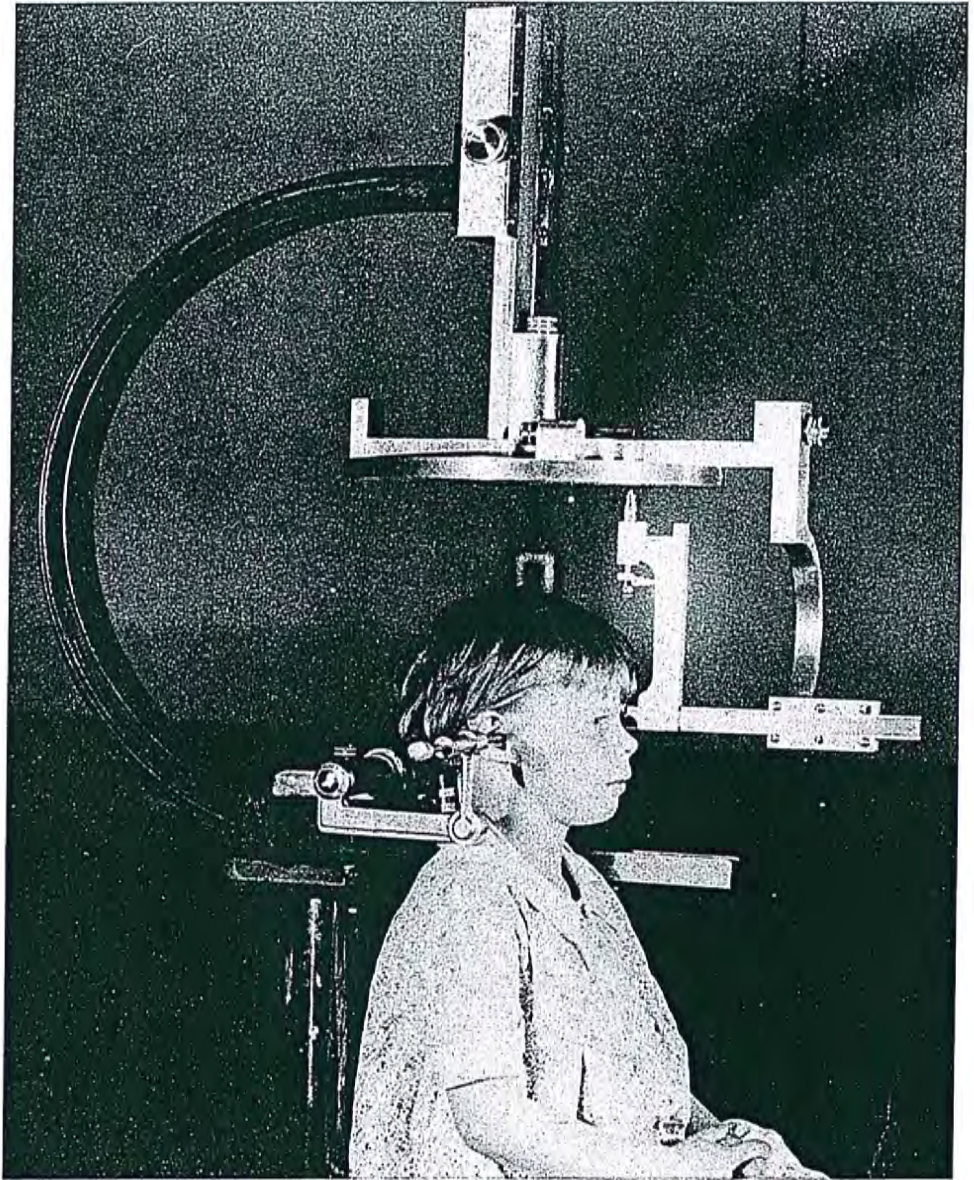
First Broadbent cephalometer, which was designed to hold the living head in a manner similar to the radiographic craniometer.
